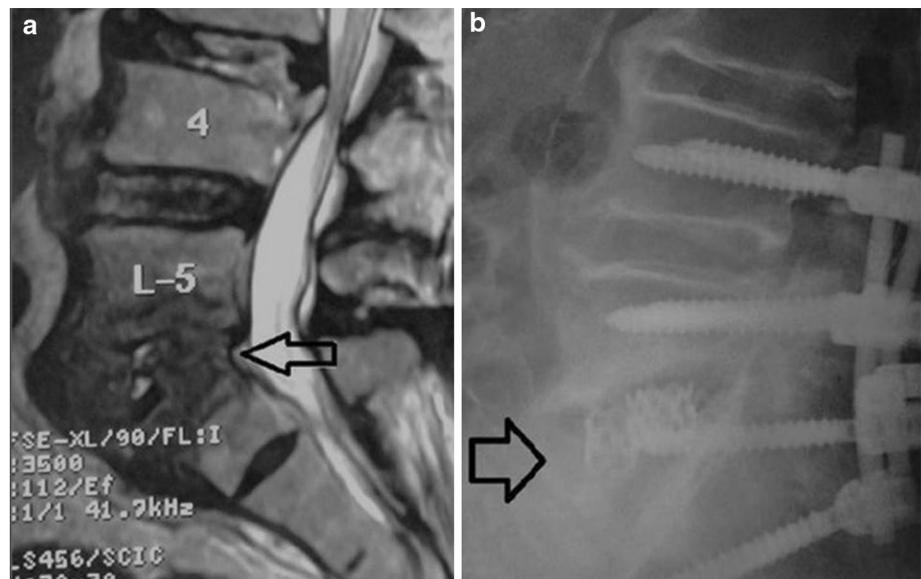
a Preoperative lateral MRI of the lumbar spine of a 44-year-old male patient (case no 2, Table 1) with drug abuse and subsequent liver insufficiency, suffering from L3–L4 spondylodiscitis (arrow) and psoas abscess due to *Staphylococcus aureus*, b 6 months postoperatively, a lateral roentgenogram of the lumbar spine (case no 2, Table 1) showing the titanium cage (arrow) in situ with segmental
